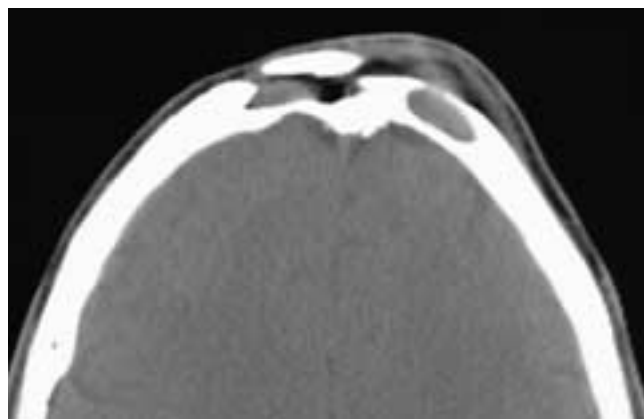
Axial CT scan of a patient who had a right osteoplastic flap procedure. There is an ovoid soft tissue density within the right sinus. The bone flap is elevated, and there is thickening of the forehead soft tissues. In addition, the left frontal sinus is opacified, and there is a soft tissue mass in the overlying forehead with thinning of the intervening anterior frontal sinus bone. This patient had a recurrent mucopyocoele in the right frontal sinus. There was a mucocoele in the nonoperated left frontal sinus.
